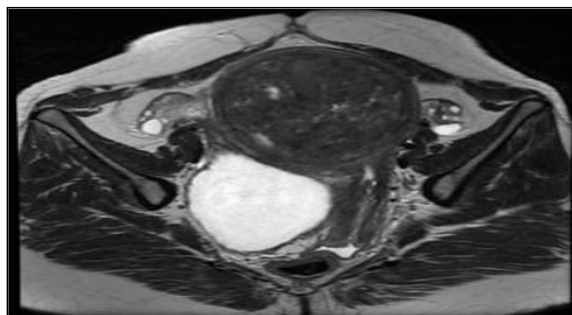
Funaki Type III — Axial T2-weighted MRI pelvis. The fibroid shows signal intensity similar to or higher than myometrium, consistent with cellular or fluid-rich tissue (UAE preferred over HIFU)
